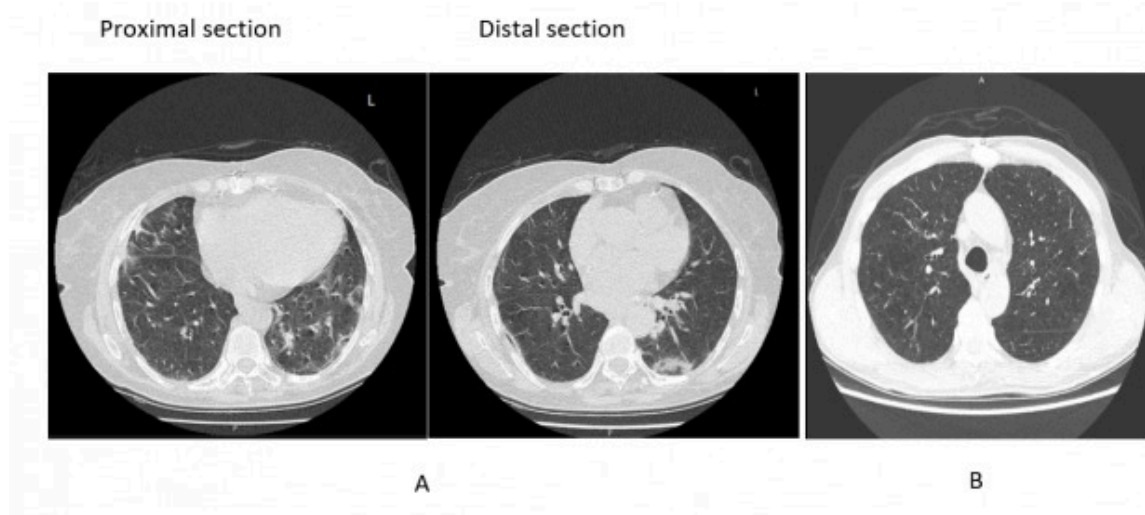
A: Case 1, Two different cross-sectional views of the ground glass areas, especially seen in the left lung, B: Case 2, Emphysema and bronchial enlargement were observed in thorax CT.
